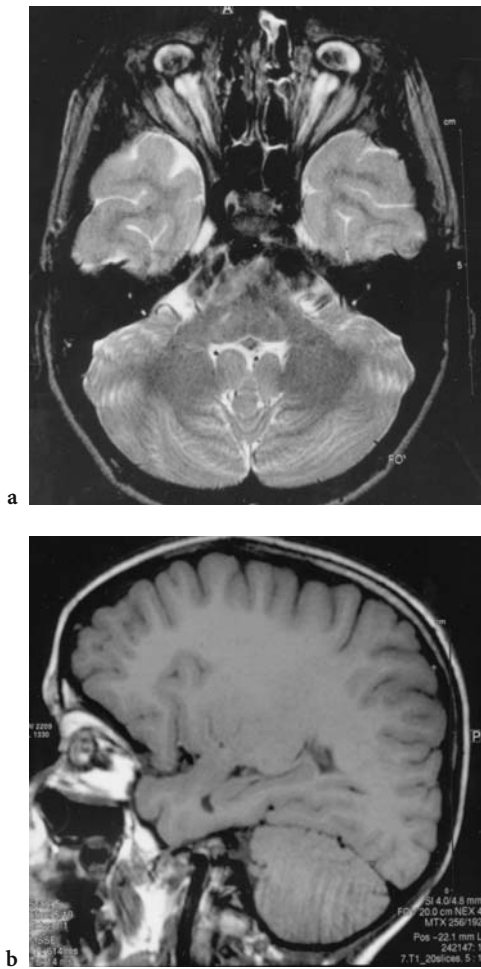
a Axial T2-weighted, b parasagittal T1-weighted MRI of a 7-year-old boy with bilateral microphthalmos, marked mental retardation and epilepsy. Normal brain anatomy
